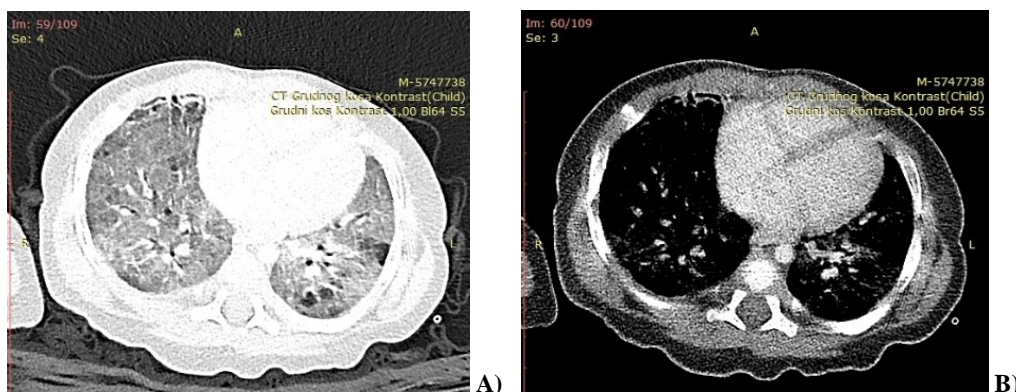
Follow-up computed tomography of the chest. No signs of pneumatocele were observed (A and B).
